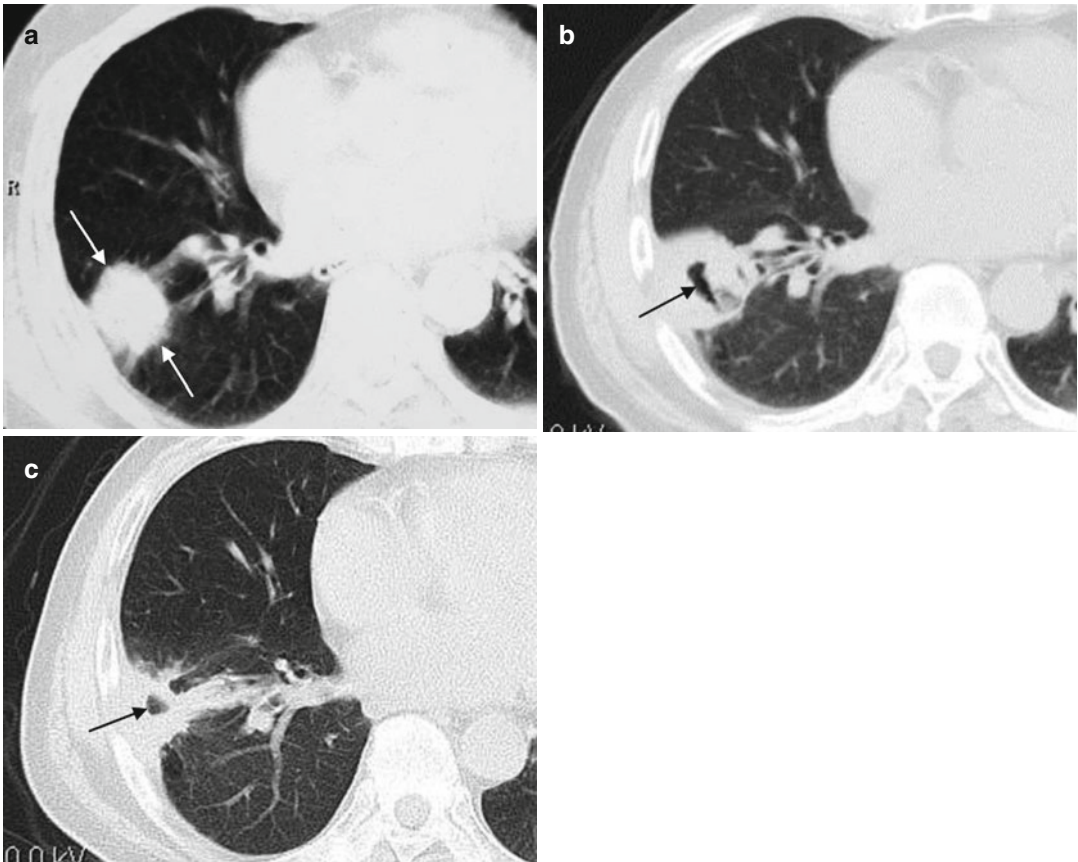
Images of a 76-year-old patient with right lobe squamous cell carcinoma who had complete response from microwave ablation. (a) Computed tomography scan pre-microwave ablation shows the approximately 3.7×2.9 cm mass with high attenuation in the right lobe (arrow). (b) Computed tomography scan at 1 month
